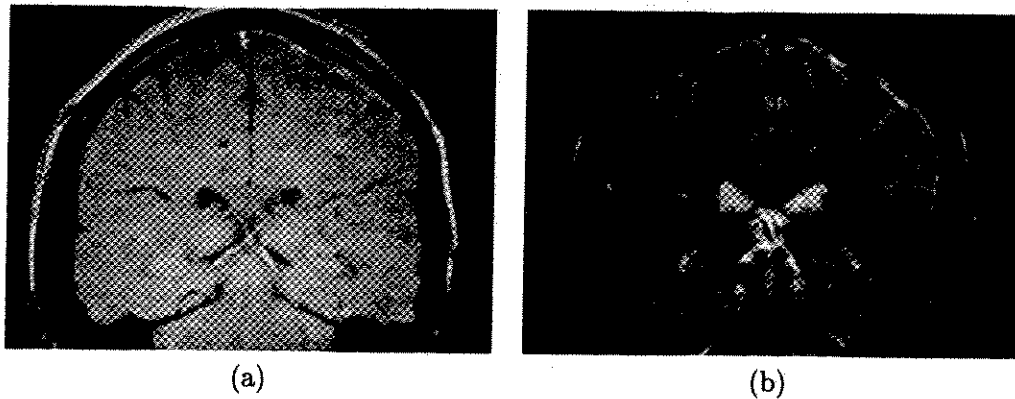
Examples of different types of MR images. (a) Proton density image. (b) T_2 weighted MR image.
